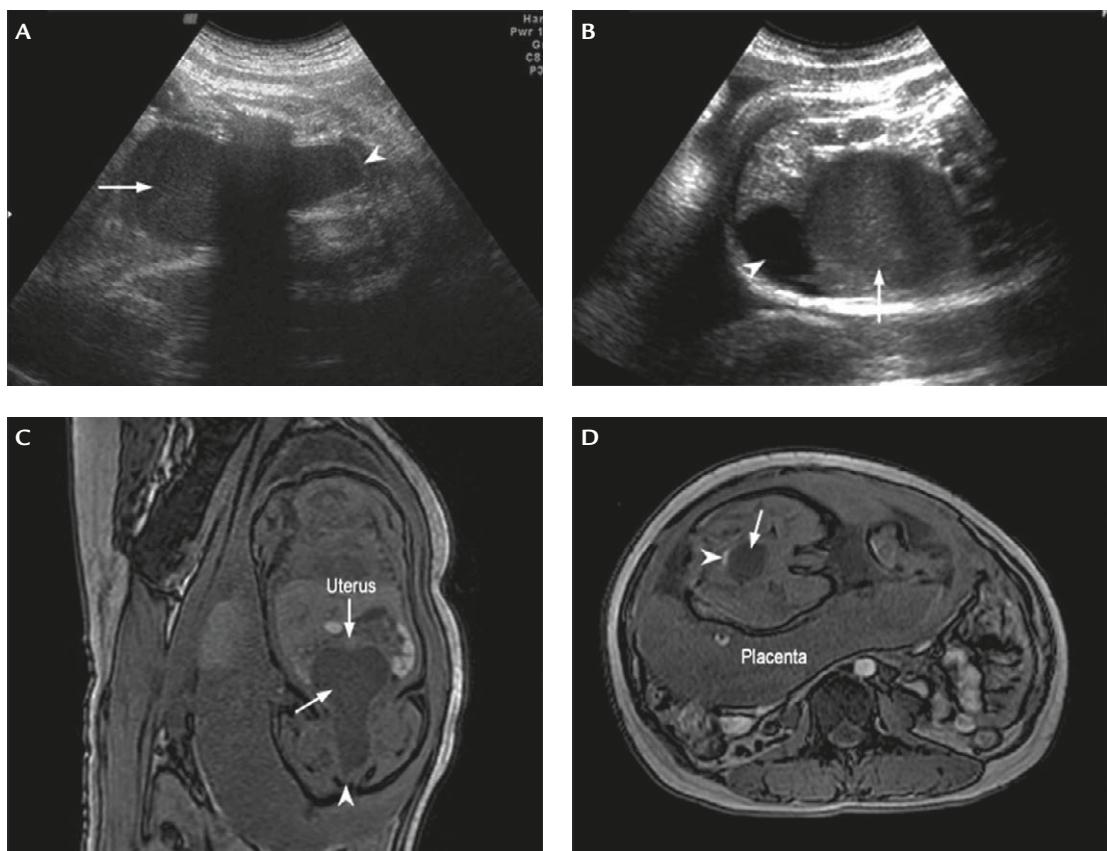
(A) Sagittal ultrasonography of the fetal pelvis shows a pear-shaped mass (arrow) presenting as a blind pouch at the distal end of the fetal vagina (arrowhead). (B) Transverse ultrasonography demonstrates a fluid-filled mass (arrow) behind the urinary bladder (arrowhead). (C) Coronal T1-weighted magnetic resonance imaging (MRI) identifies the uterus without fluid accumulation visible at the top of the mass (arrows). The arrowhead indicates the membranal protrusion of the introitus. (D) Axial T1-weighted MRI shows a hyperintense intrarectal signal (arrowhead) behind the hydrocolpos (arrow).
